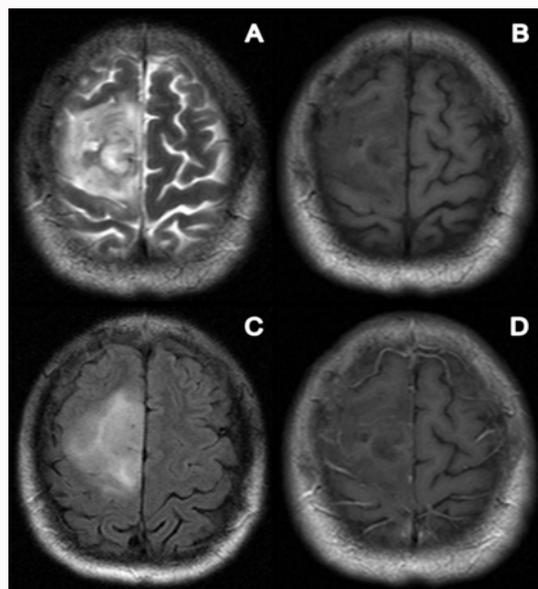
Male, 31 years-old, admitted to the hospital because of frequent dizziness and headache. Mixed cystic-solid PXA pattern. MRI mainly demonstrates several mixed cystic-solid lesions in the junction of the right frontal and parietal lobe. (A) The lesion is slightly hyperintense, hyperintense with mild peritumoral edema on unenhanced T2-weighted images. (B) Unenhanced axial T1-weighted image shows hypointense, isointense lesions. (C) FLAIR-weighted image show slightly hyperintense lesions. (D) No contrast enhancement of the lesion on enhanced T1-weighted image.
